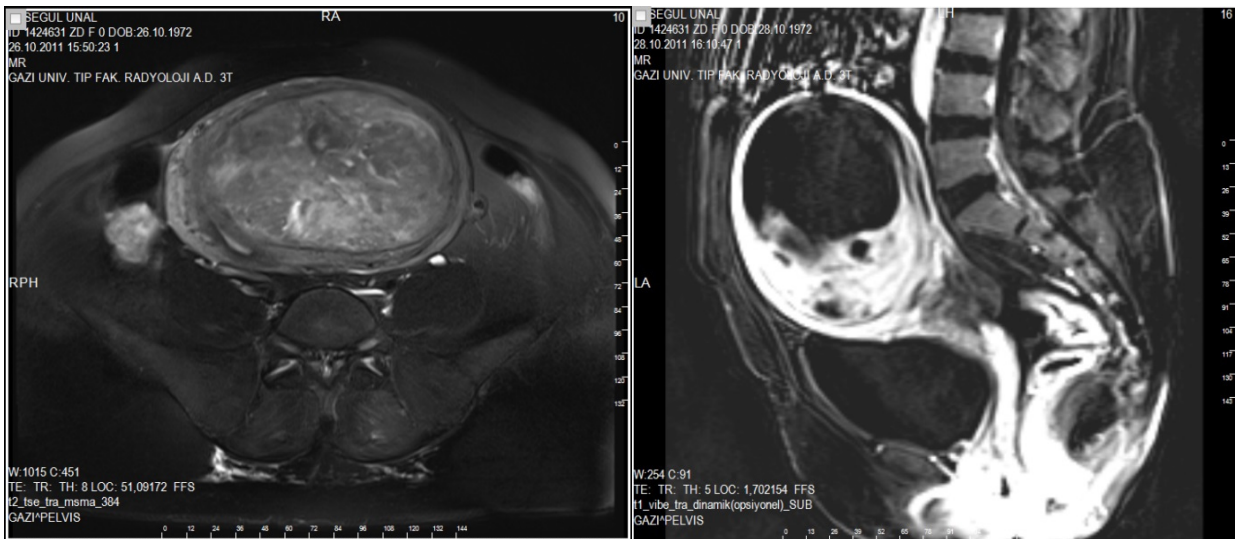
Patient AU: MR image of the pre and post-embolization leiomyoma.
